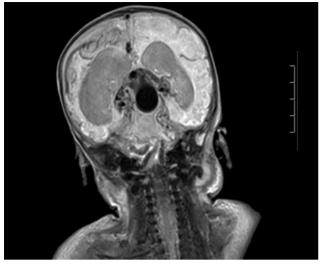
Magnetic resonance imaging, TI-weighted coronal cross-section revealing dilation of both lateral ventricles and the vein of Galen aneurysmal malformation.
